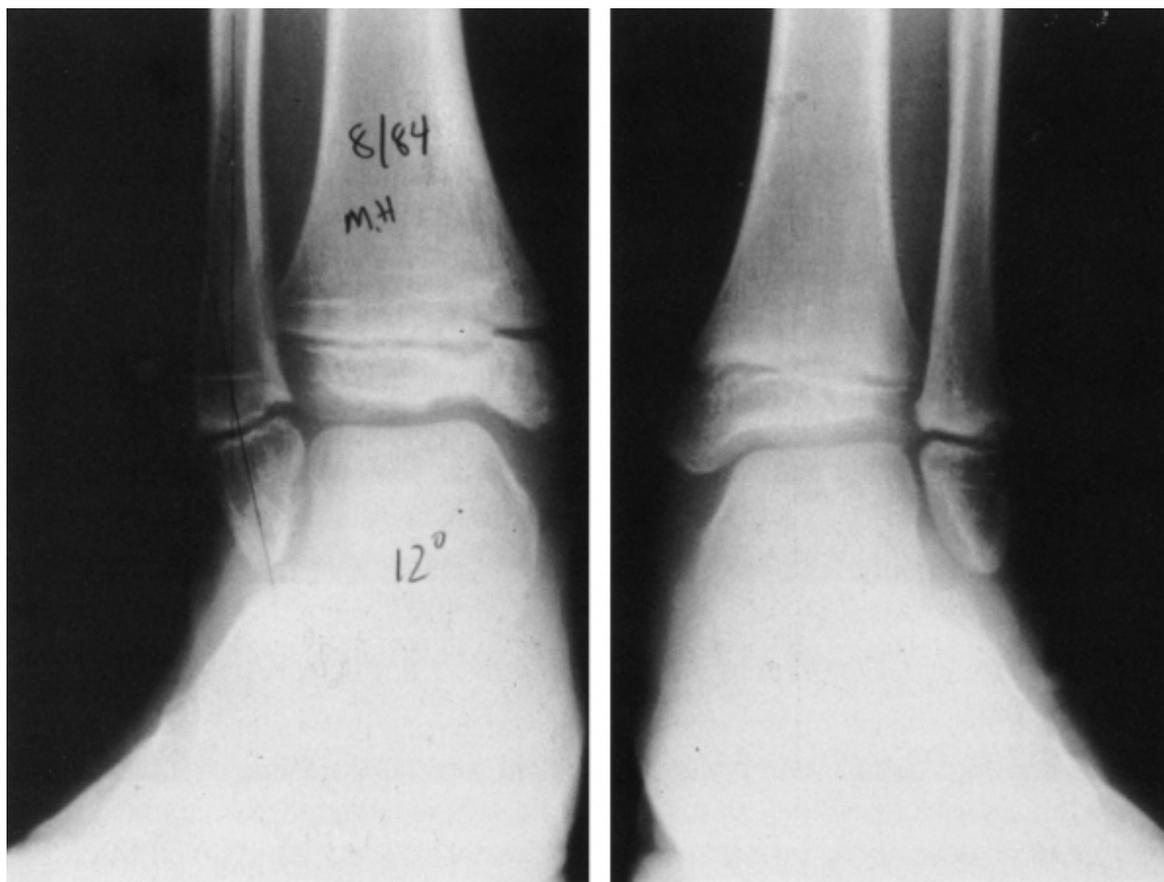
Figure 25C2-11 This patient sustained a Salter-Harris IV medial malleolar fracture, which was treated closed. The patient was referred 6 months after injury, at which time she had trouble remembering which ankle had been injured. These radiographs were taken 18 months after the injury. Resection of a bony bridge and interposition were required. She resumed growth, and the fibular angular deformity had been corrected. Note the irregular Harris growth arrest lines.
